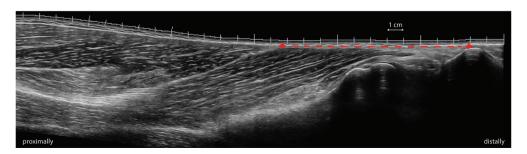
Example of extended field of view ultrasound image of biceps femoris long head. Tendon length is marked with a dashed red line. The arrows indicate the distal musculotendinous junction and the insertion of the biceps femoris long head on the head of the fibula.
